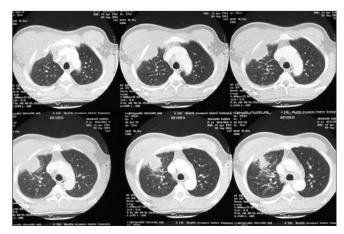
CT-scan of the chest demonstrating a radiopaque lesion in the right upper lobe.
